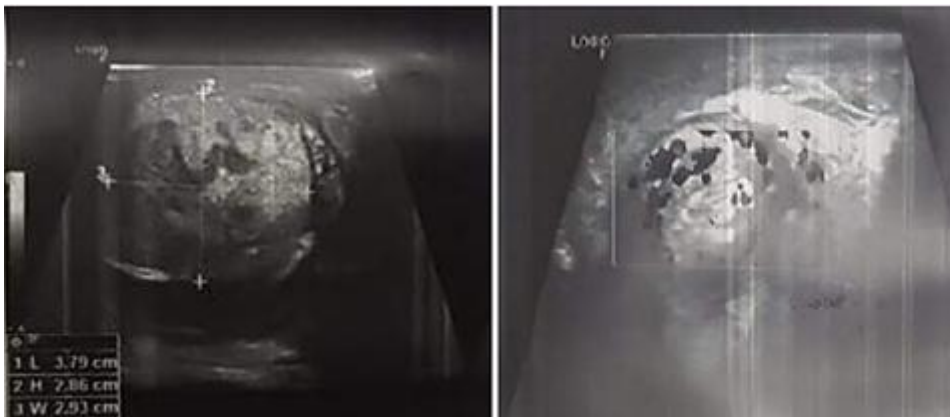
Ultrasound showed an enlarged left testicle with regular contours and hypoechoic, heterogeneous, poorly defined areas and the the absence of vascular supply with a twisting spiral.
